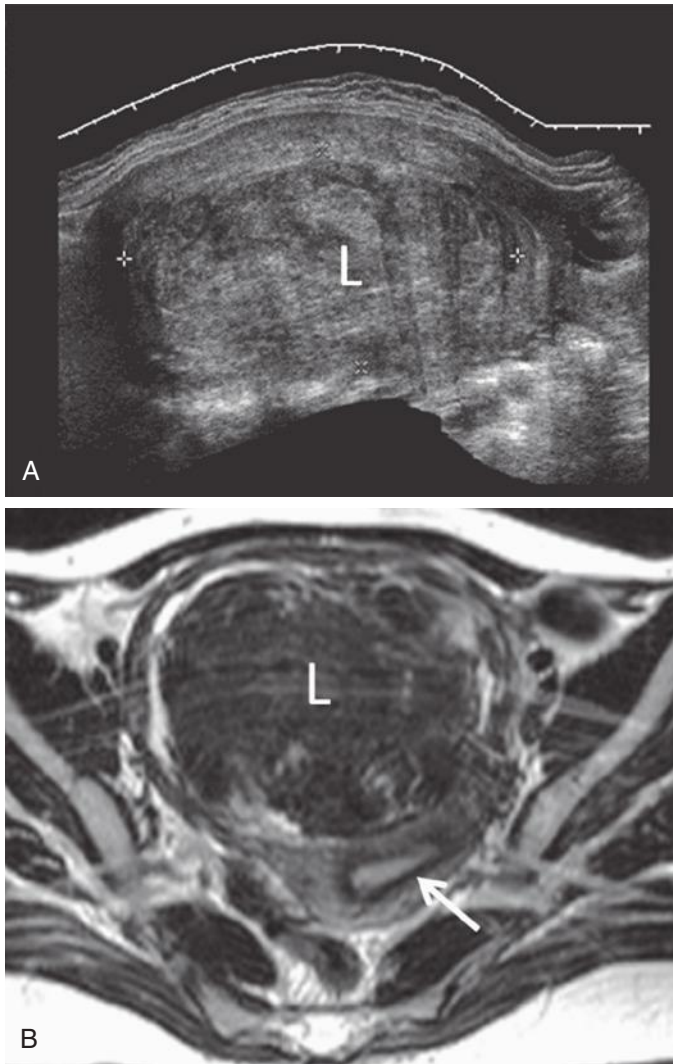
Large intramural leiomyoma. A, Extended field of view ultrasound image demonstrates a large (18.3 cm) leiomyoma (L and calipers) occupying most of the uterus. The relationship to the endometrium, which is not visualized, cannot be determined. B, T2-weighted axial magnetic resonance image demonstrates that the large leiomyoma (L) is intramural in location. The high signal intensity endometrium (arrow) is delineated, shown to be displaced posteriorly but otherwise unremarkable.
